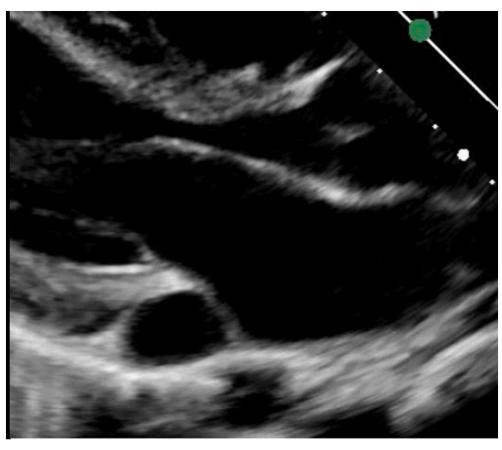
Parasternal long axis - coronary sinus (CS) dilation.
